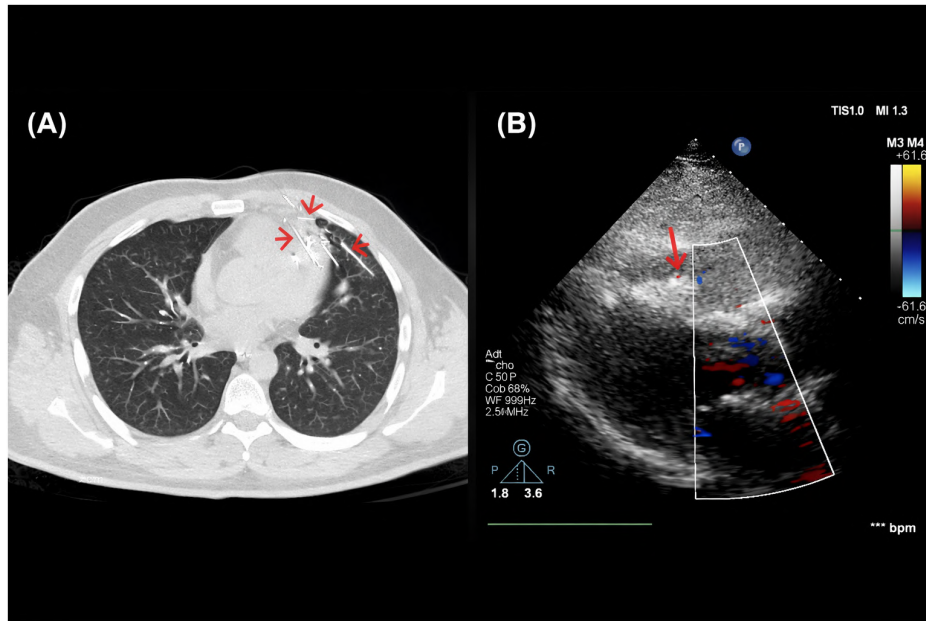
(A) Axial computed tomography demonstrating a sewing needle penetrating the interventricular septum. (B) Transthoracic echocardiography confirming septal myocardial involvement.
